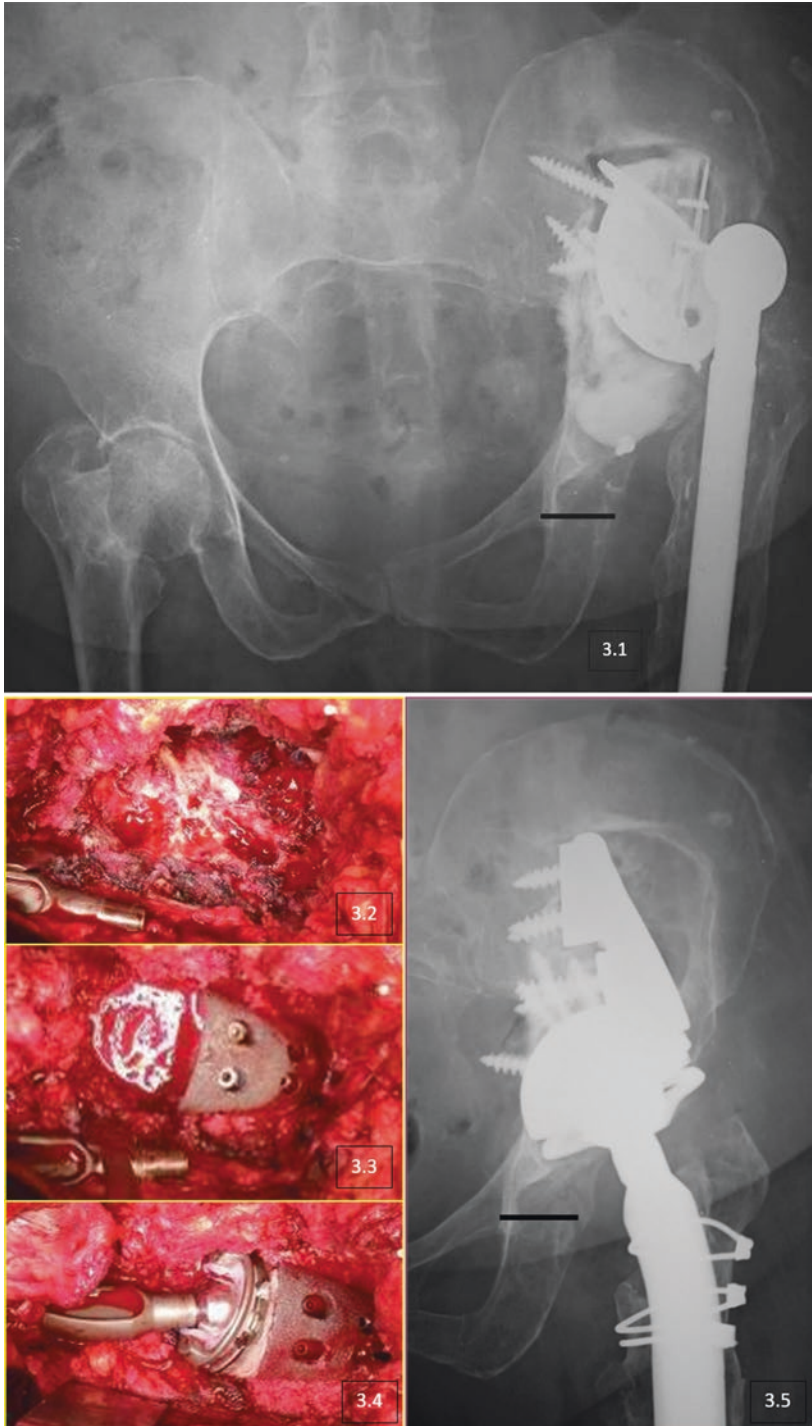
3.1: Acetabular defects Paprosky type IIIA without pelvic discontinuity. 3.2–3.4: Intraoperative views. 3.5: Postoperative radiograph reconstruction: trabecular metal and iliac augments with supplements blocks
